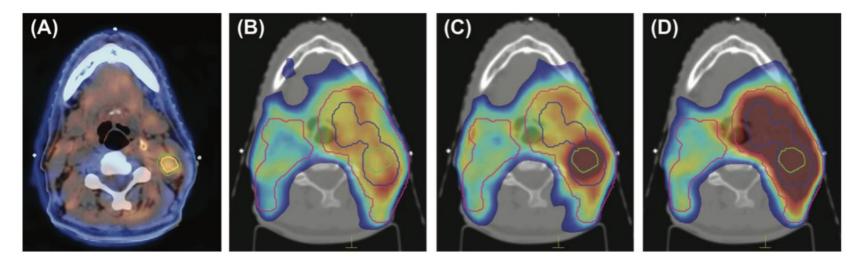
The FMISO PET/CT scan of a patient with a T3N2b oropharyngeal squamous cell carcinoma is shown (A). The GTVH, PTVH, PTV3 and PTV1 are outlined in yellow, green, blue and red, respectively. The dose distributions for the STD plan (B), the HDP plan (C) and the UDE plan (D) are demonstrated using 'colorwash' with red indicating higher doses and blue indicating lower doses.
